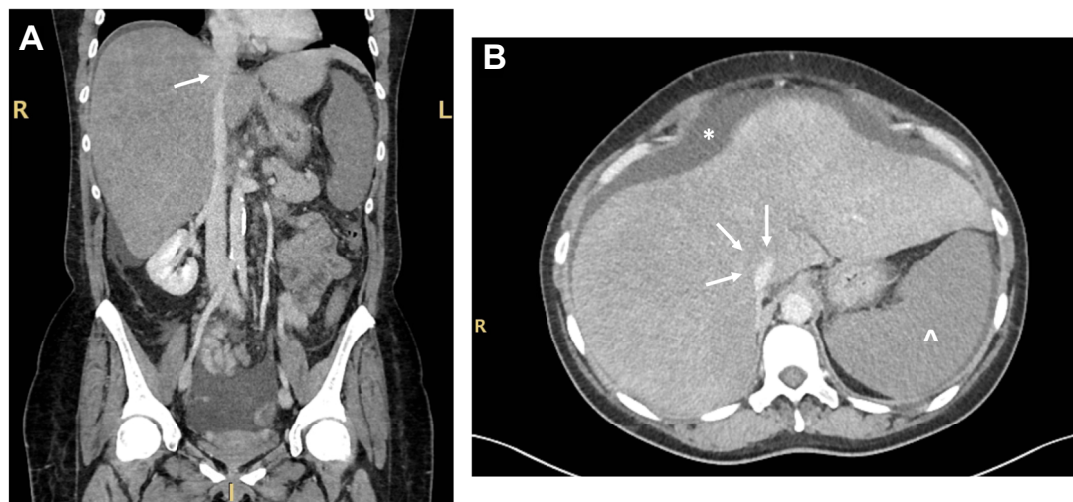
Abdominal CT scan. The CT scan showed an enlarged, dysmorphic liver, compression of the retro-hepatic inferior vena cava (arrow, A), splenomegaly (\blacktriangle , B), and ascites ($*$, B); hepatic veins were abnormal, compressed by the liver parenchyma, and not clearly visible in the venous phase (arrows, B).
